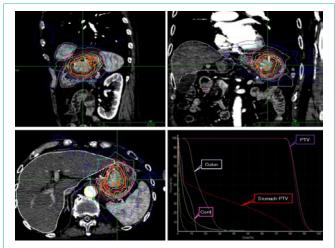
Dosimetric evaluation of computed tomography (CT) images show the dose distribution in the sagittal, coronal, and axial slices, with a D95 isodose involving the tumor. We planned to concentrate the high dose on the target. The lower right figure is a dose-volume histogram (DVH).
